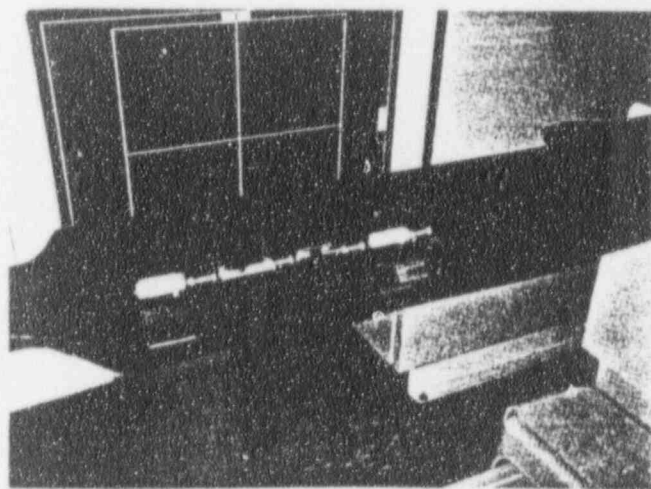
Placement of syringe shields for a trial of SPECT acquisitions
